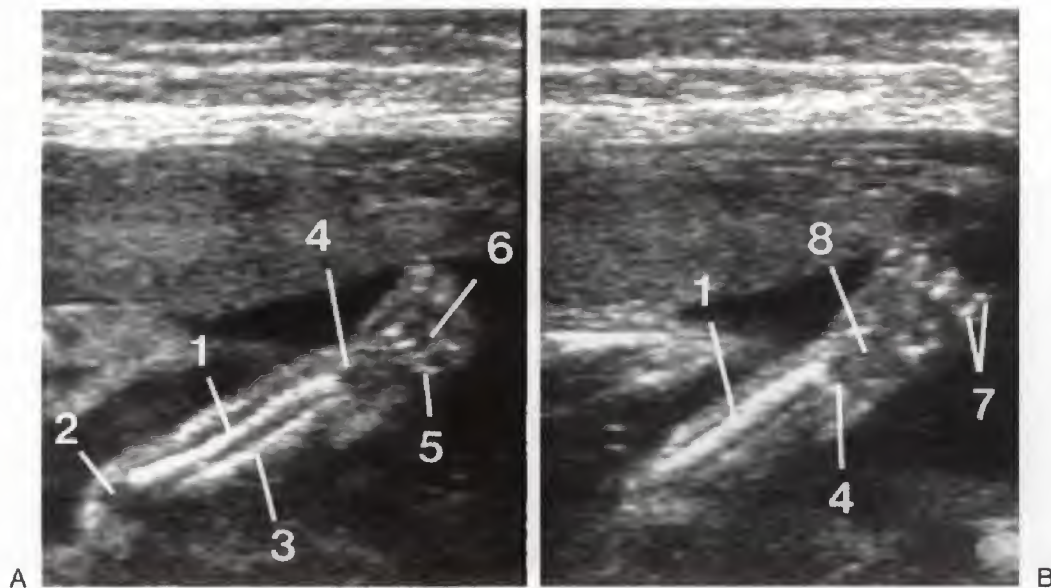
Fetal elbow, hand pronated, coronal sonogram. 1, triceps muscle; 2, ossified humeral diaphysis; 3, cartilaginous olecranon fossa; 4, conglomerate cartilages about the elbow joint; 5, proximal ulnar diaphysis; 6, medial humeral epicondyle.
